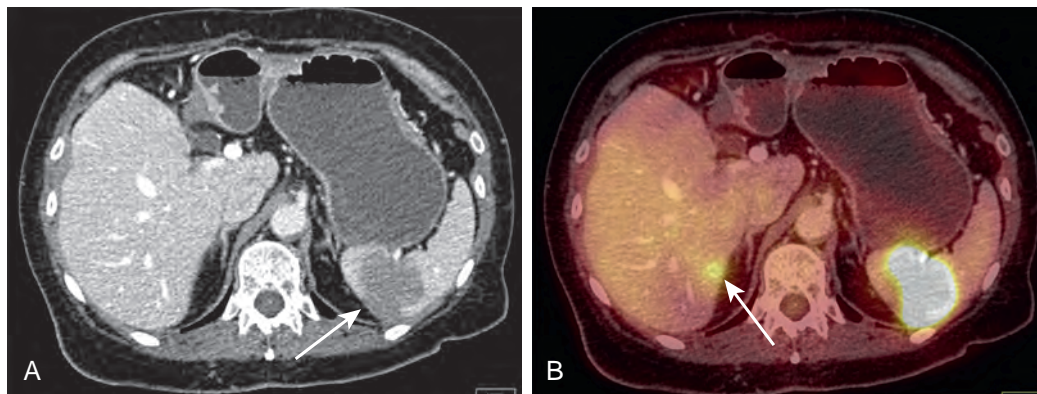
Splenic metastasis. A. Contrast-enhanced CT demonstrates a low-attenuation mass in the spleen (arrow). B. This splenic mass demonstrates increased FDG avidity on PET/CT. Findings are consistent with a splenic metastasis in a patient with known colon carcinoma. The apparent focal area of FDG uptake in the periphery of the liver (arrow) without a CT correlate is due to misregistration from excreted FDG in the right renal collecting system.
